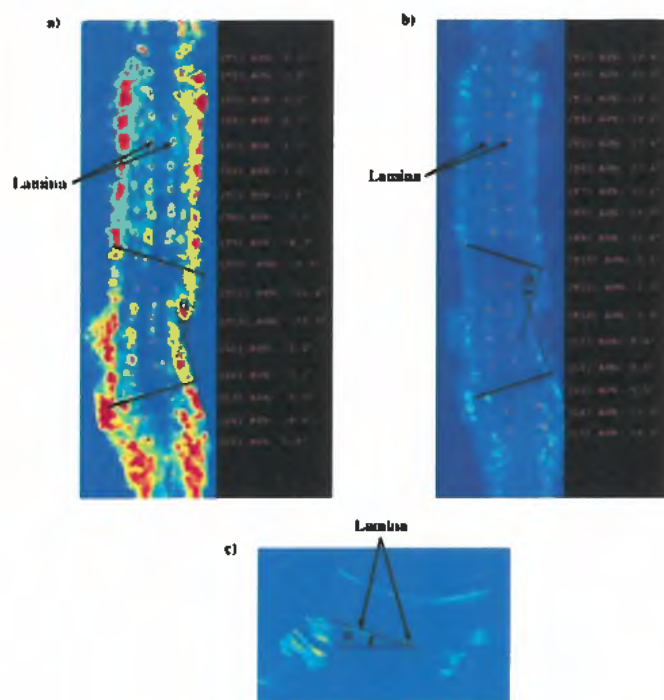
Ultrasound Cobb angle measurements (θ) on a) the coronal plane, b) the plane of maximum deformity, including values for the VAR (α) of each vertebra, and c) the transverse plane.
